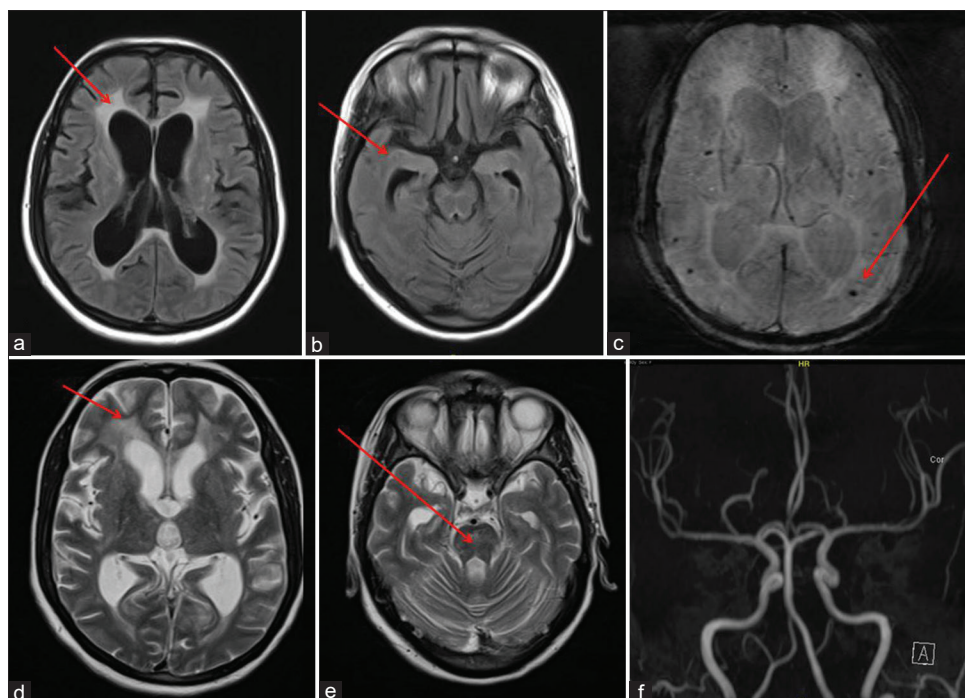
Brain magnetic resonance imaging (a) axial fluid-attenuated inversion recovery (FLAIR) image shows hyperintensity (red arrow) in periventricular white matter with prominent lateral ventricle sparing subcortical U fibers; (b) axial FLAIR image shows absence of signal change in anterior temporal lobe; (c) susceptibility-weighted image shows microbleeds (red arrow); (d) axial T2 image shows hyperintensity (red arrow) in periventricular white matter with prominent lateral ventricle sparing subcortical U fibers; (e) axial T2 image shows pontine hyperintense signal change (red arrow); (f) MR angiogram with normal intracranial arteries
